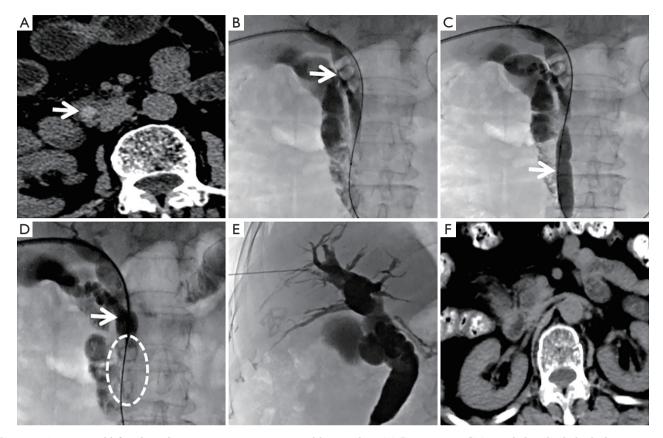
A 75-year-old female with epigastric pain accompanied by jaundice. (A) Preoperative CT revealed multiple high-density stones in the bile duct (arrow); (B) intraoperative puncture of the bile duct revealed 3 stones (arrow) in the common bile duct, with a maximum diameter of 1.3 cm; (C) 14 mm × 4 cm balloon dilating Vatter ampulla; (D) Fogarty balloon (arrow) filled up to 1.4–1.6 cm above the stone, allowing the stone (white circle) to be gradually pushed into the duodenum under fluoroscopy; (E) postoperative angiography showed that the stones in the bile duct had disappeared; (F) no high-density stones were found in the bile duct 3 days after surgery. CT, computed tomography.
